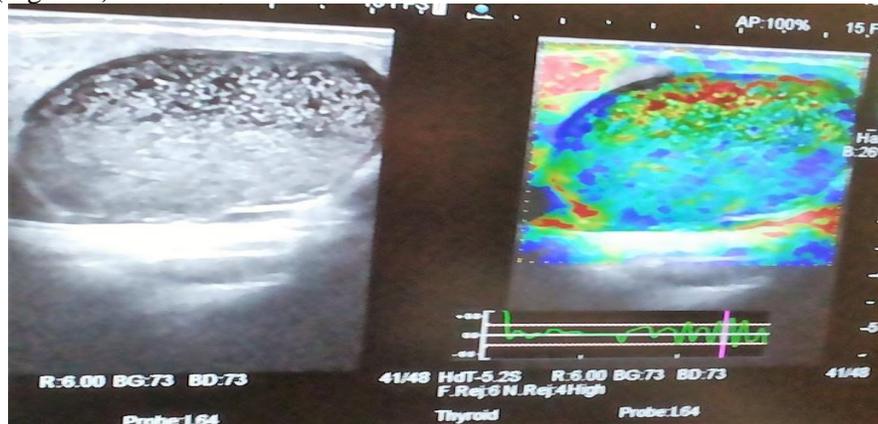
Ultrasonography and Elastography images showing floating echogeneity on ultrasound and Elastographic Score 2 on Elastography.
